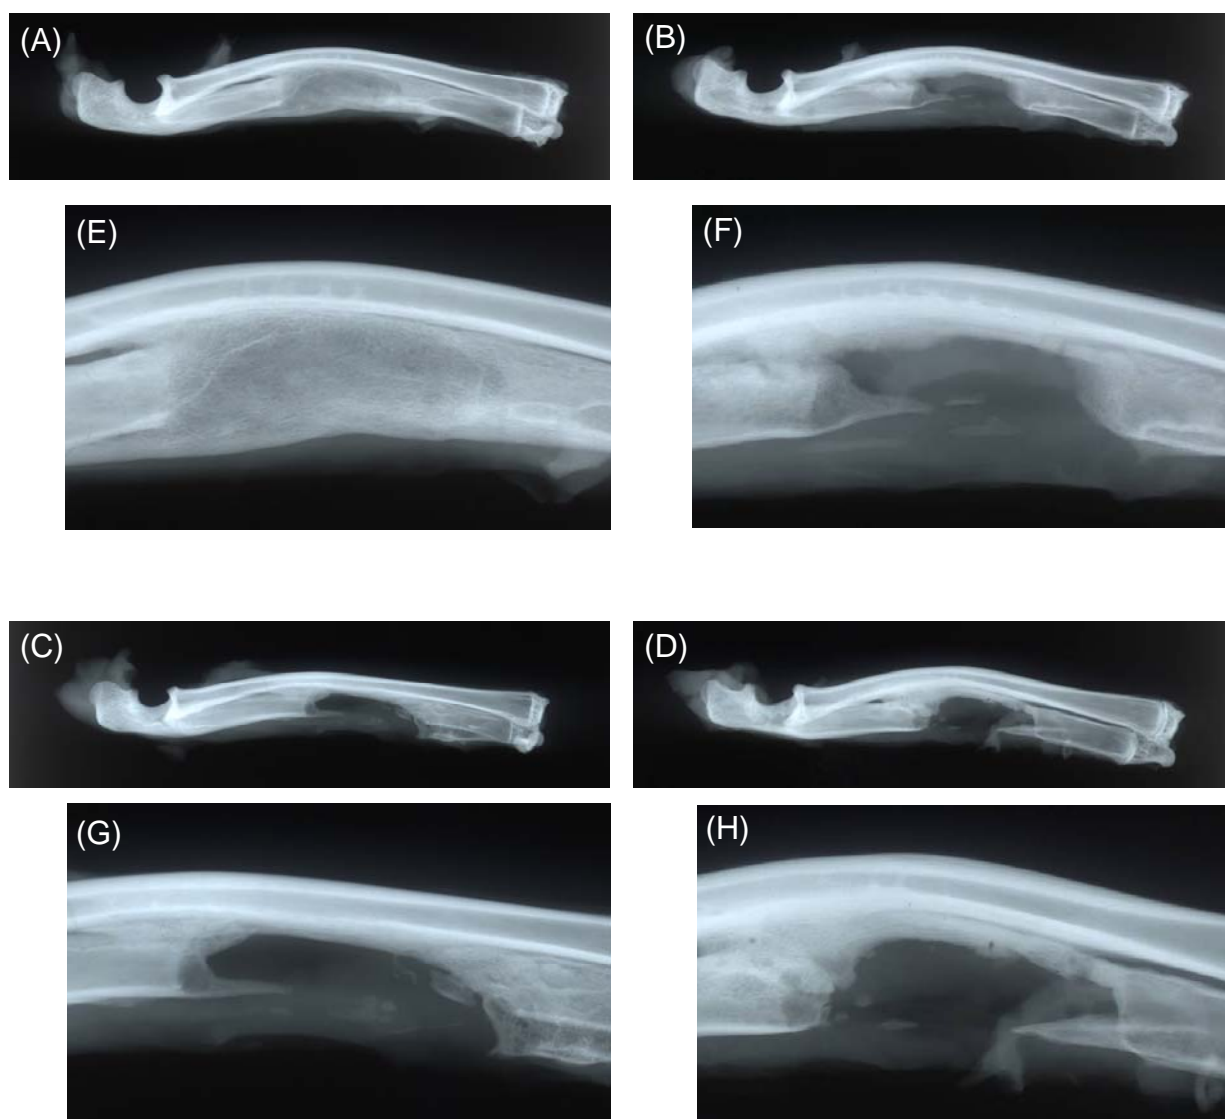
Radiographic appearance of ulna defects 6 weeks after application with a gelatin hydrogel incorporating BMP-2 (A and E), an empty gelatin hydrogel (B and F), and free BMP-2 (C and G) or an empty defect without free BMP-2 (D and H) at magnification $\times 1$ (A-D) and 2 (E-H). The water content of hydrogels used was 97.8 wt% and the BMP-2 dose was 17 $\mu\text{g}/\text{site}$.
